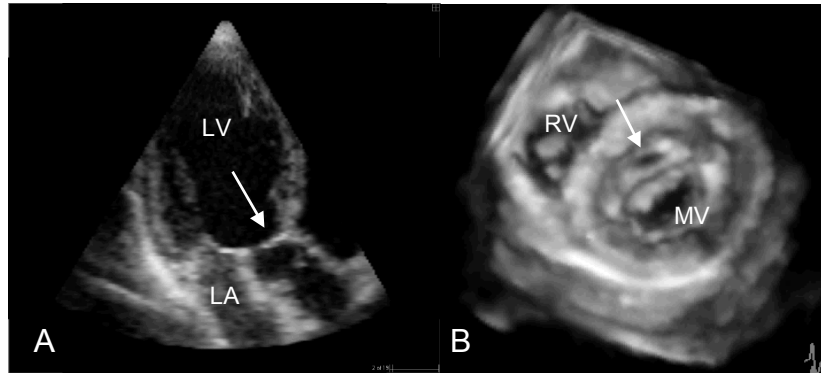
A: Two-dimensional echocardiogram of severe subvalvular aortic stenosis (arrow). Note that the left ventricular outflow area cannot be measured.
